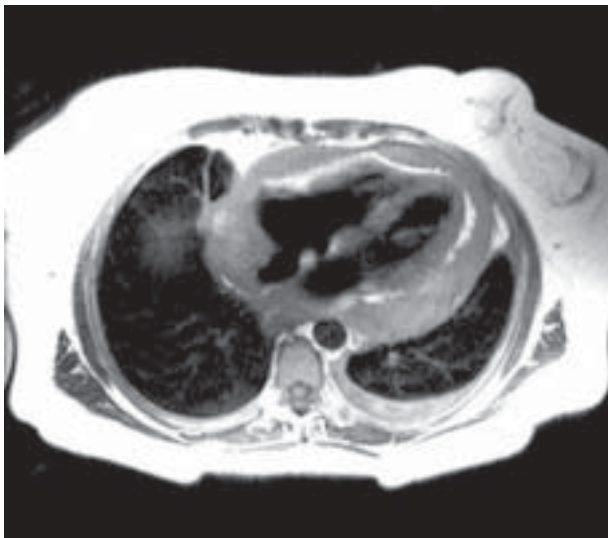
MRI Proton Density (Double IR) showing an isointense mass in right atrium wall, invading surrounding structures and also pericardial effusion
